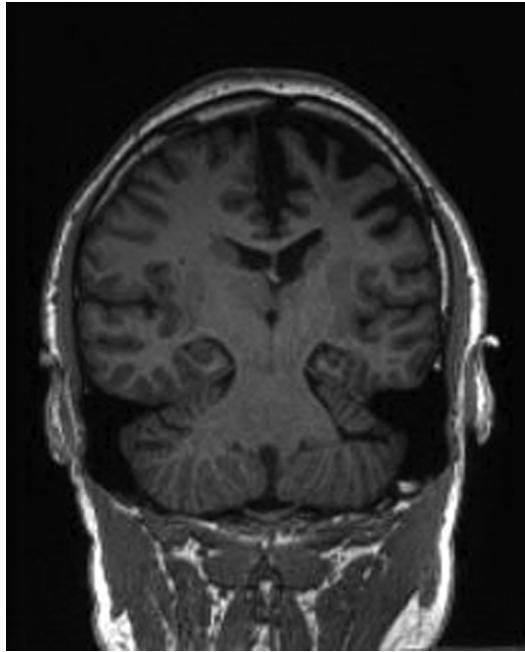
Patient with left medial temporal lobe epilepsy. MRI head seizure protocol T1-weighted image in the oblique-coronal plane shows volume loss involving the left hippocampal formation and left mesial temporal lobe compatible with MTS. Encephalomalacia within the posterior superior left frontal lobe presumably related to remote meningioma resection. Patient is seizure-free after a left selective amygdalohippocampectomy. Note the left temporal lobe is on the right side of the figure.
